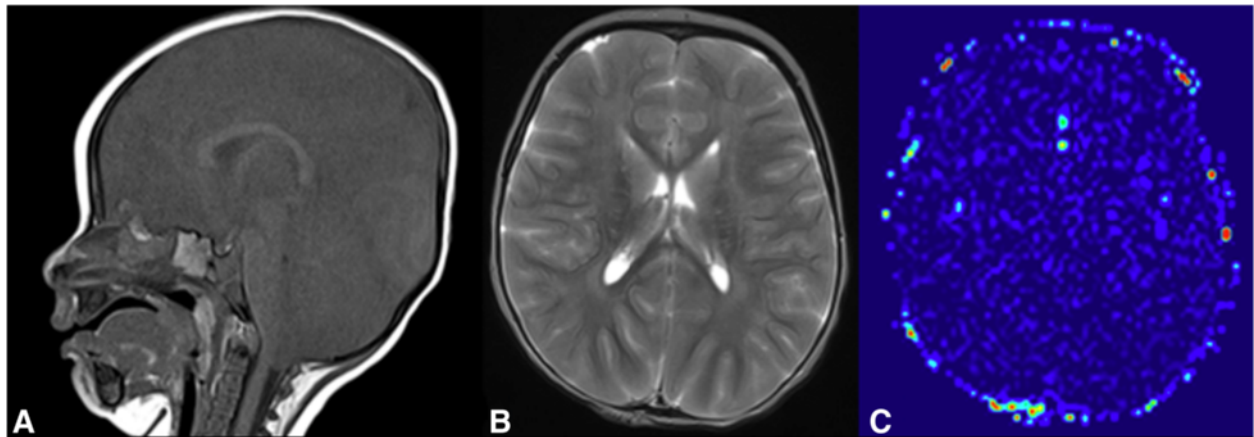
Patient 1. a Sagittal T1-weighted images demonstrating severe cerebellar edema with brainstem compression and foramen magnum herniation. b The T2-weighted axial brain slice shows bilateral basal ganglia necrosis. c The dynamic susceptibility contrast MRI cerebral blood volume map shows a lack of brain perfusion, but preserved perfusion of the scalp, which belongs to the perfusion territory of the external carotid artery
